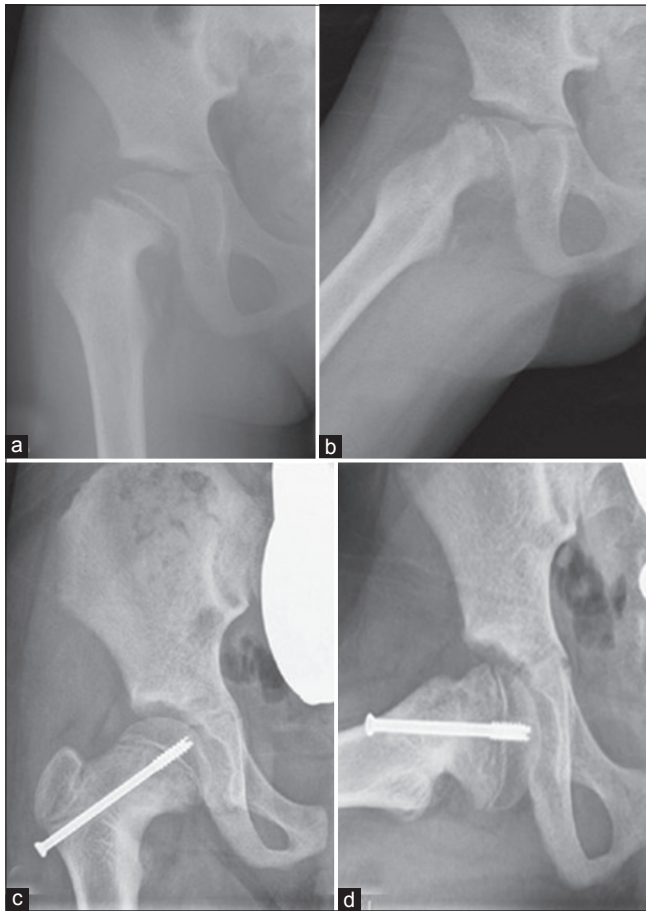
Radiographs (anteroposterior & frog leg lateral views) showing slipped capital femoral epiphysis (Rt) (a,b) in 8-year-old female child at the initial presentation; (c,d) radiographs (anteroposterior and frog leg lateral showing good remodeling of the head of the femur after the surgical fixation and alfacalcidol treatment during follow up (2 years after initial presentation)
